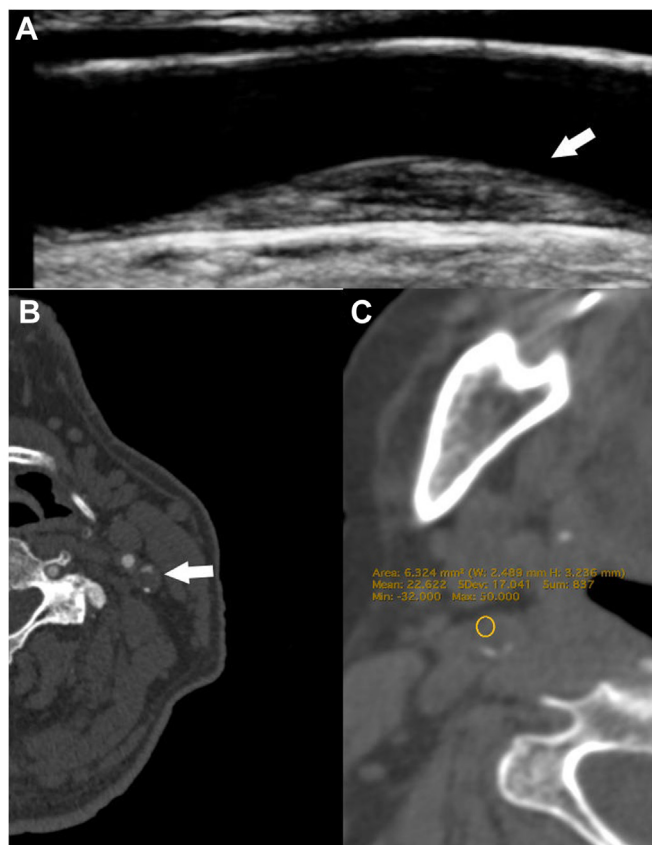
Examples of lipid rich necrotic core using ultrasound (US) examination (A) and computed tomography (CT) scan (B, C). (A) Nonstenosing carotid plaque with a lipid-rich necrotic core (LRNC) and thick fibrous cap (FC) in the left common carotid artery of a 62-year-old woman with an ipsilateral ischemic stroke. (B) Low-attenuation, subocclusive plaque with a mean Hounsfield unit (HU) value of 43 HU in the left internal carotid artery resembling a LRNC, in a symptomatic 82-year-old man. (C) Low-attenuation, subocclusive plaque with a mean HU value of 22 HU in the right internal carotid artery of a 72-year-old man with an ipsilateral ischemic stroke. However, owing to the HU overlap between lipid and hemorrhage components, intraplaque hemorrhage (IPH) cannot be excluded.
